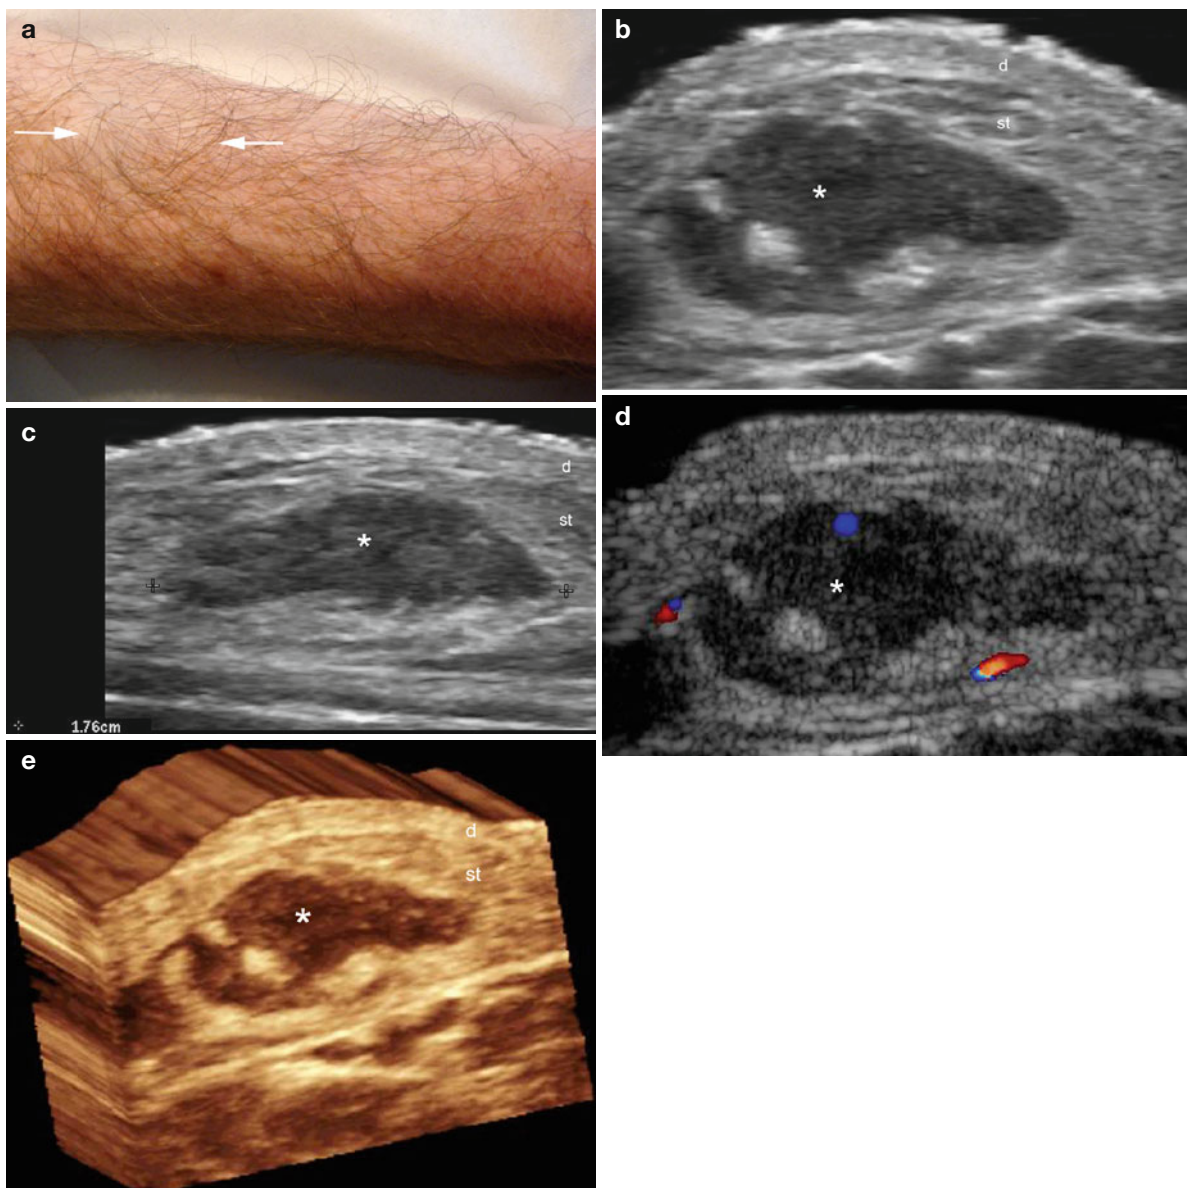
(a–e) Nodular fasciitis. (a) Clinical image shows a skin-colored palpable lump (*arrows*) in the palmar aspect of the right forearm. (b) Grey scale ultrasound image (transverse view) demonstrates an oval-shaped hypoechoic and heterogeneous solid nodule (*) in the subcutaneous tissue. (c) Grey scale ultrasound image (longitudinal view)
